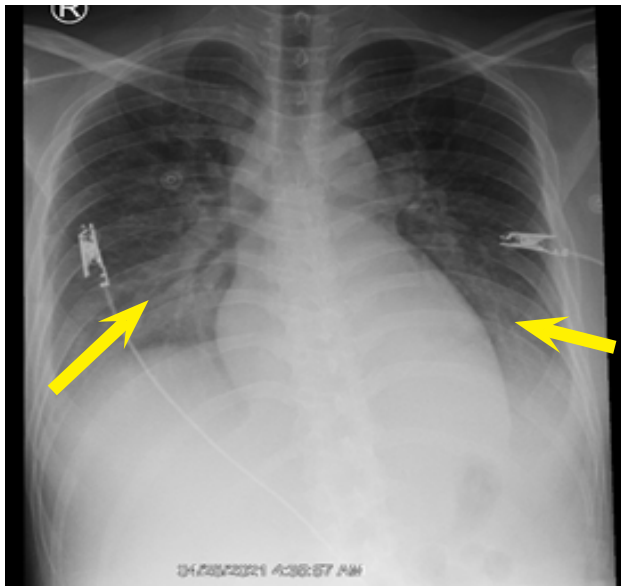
Hazy densities in both lower lungs seen on chest x-ray (yellow arrows).
